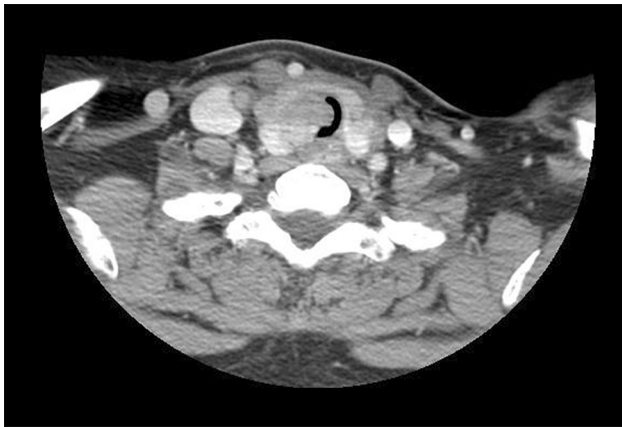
Axial computed tomography scan shows tracheal intraluminal invasion of the thyroid carcinoma resulting in severe tracheal stenosis
